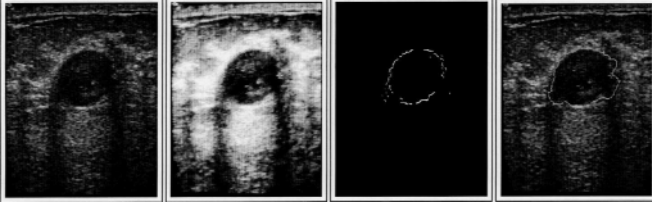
Examples breast ultrasound from Madabhushi and Metaxas [73]. From left to right: original image, contrast-enhanced version, detected boundary points and the output of deformable model.
